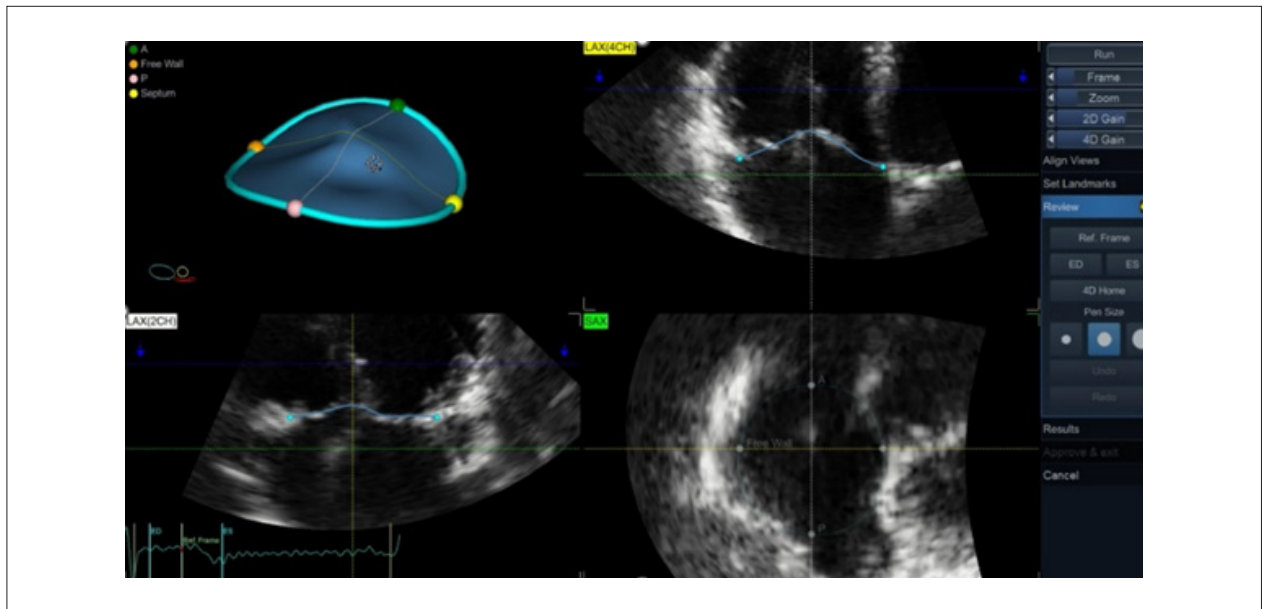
Three-dimensional multiplanar reconstruction of the tricuspid valve by 3D echocardiography, showing the spatial model of the annulus with anatomical reference points (apex, septum, free wall, and commissures). Orthogonal cuts (LAX 4-chamber, LAX 2-chamber, and SAX transverse) allow for precise contour adjustment and detailed analysis of valve geometry.
